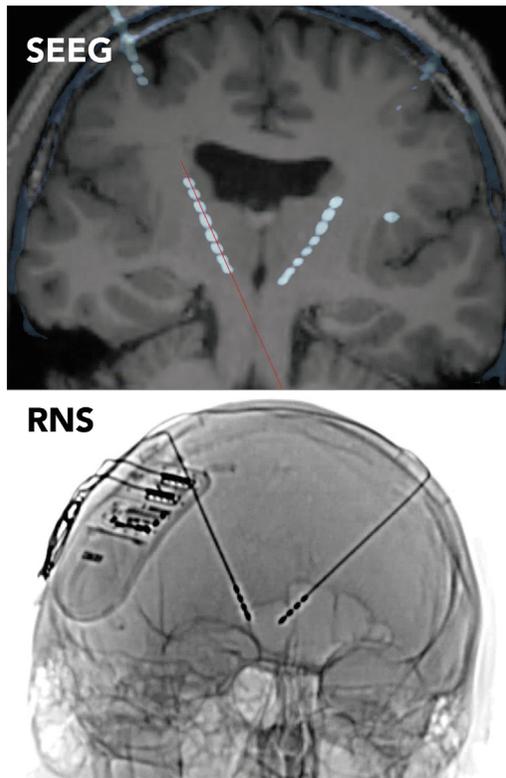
Thalamic implantation during SEEG. Post-SEEG implantation CT fused to the preoperative brain MRI, demonstrating the position of the frontothalamic SEEG leads (*top*). The orientation and SEEG lead trajectories chosen for this patient were the same as that planned for use with transfrontal implantation of bilateral thalamic leads for RNS (*bottom*).
